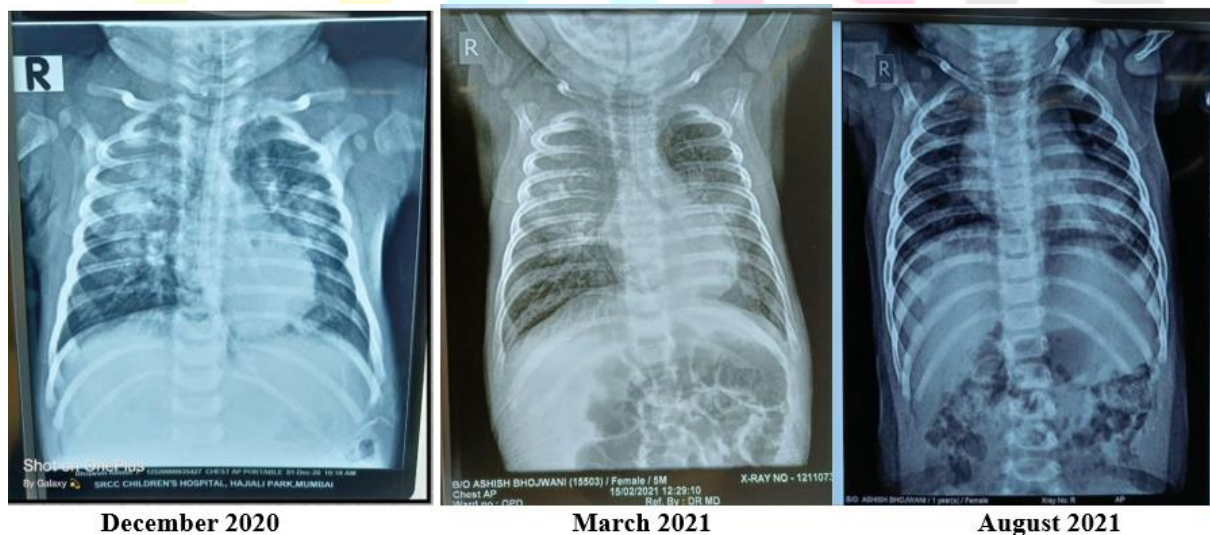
Chest x-rays of patient
